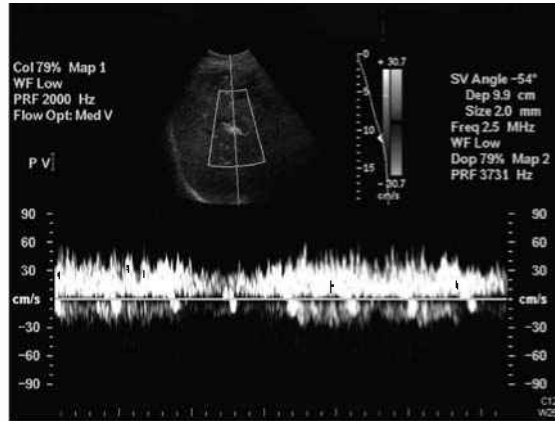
Postoperative Doppler US image shows good flow in the portal vein with peak velocity of approximately 40 cm/sec.
